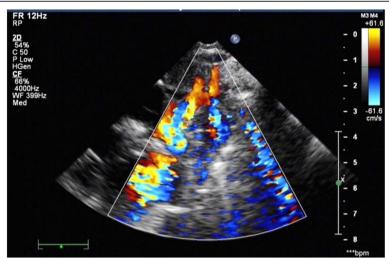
Echocardiography revealing abnormalities. Abnormalities include dextrocardia, an ostium secundum atrial septal defect with bidirectional shunt, and a ventricular septal defect with main right-to-left shunt.
